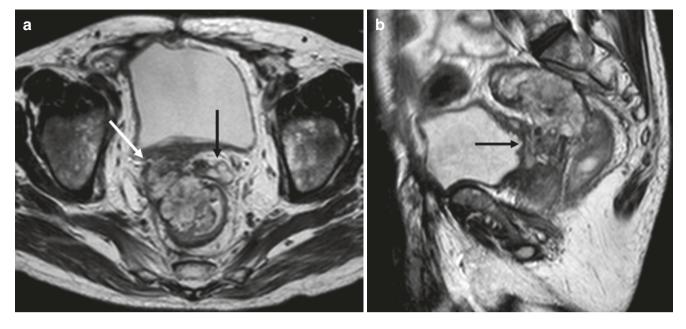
MRI of a T4 tumor. (a). Axial and (b). sagittal T2 images show a bright, therefore mucinous, rectal cancer with direct invasion of the right seminal vesicle (white arrow); black arrow shows the normal left seminal vesicle which is fluid filled. (Courtesy of Vincent Pelsser, MD)
